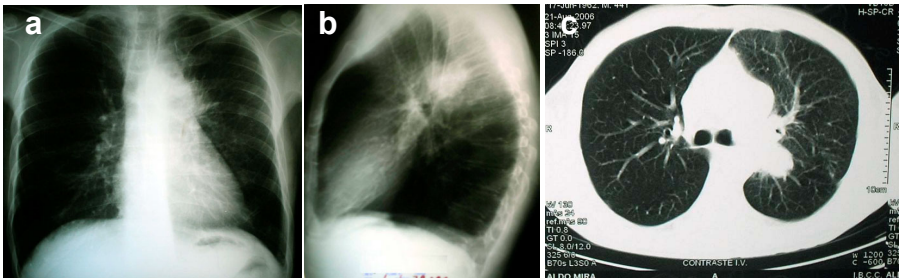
Enlargement of left hilar lymph node in an HIV-infected patient. a and b: chest X-ray, c: computerized tomography.
